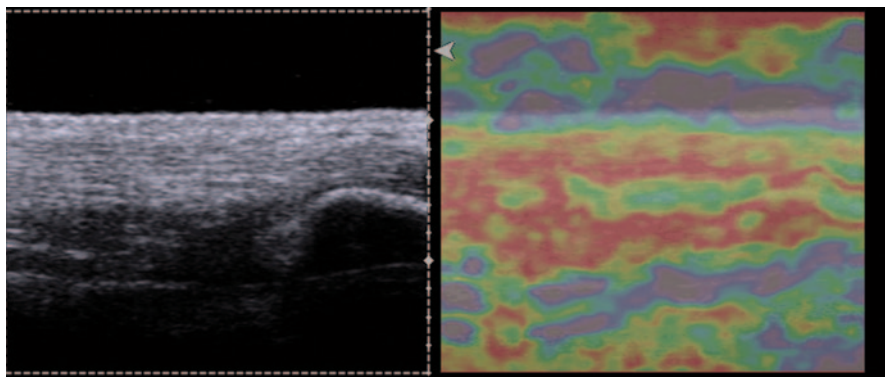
Sonoelastography and B-mode US of a normal tendoachilles showing normal sonographic pattern on B-mode (*left*). The sonoelastogram obtained (*right*) is displayed as a color mask that was superimposed on the conventional B-mode image. (Photo copyright [Chueh-Hung Wu and Tyng-Guey Wang]. All rights reserved. Used with permission)
